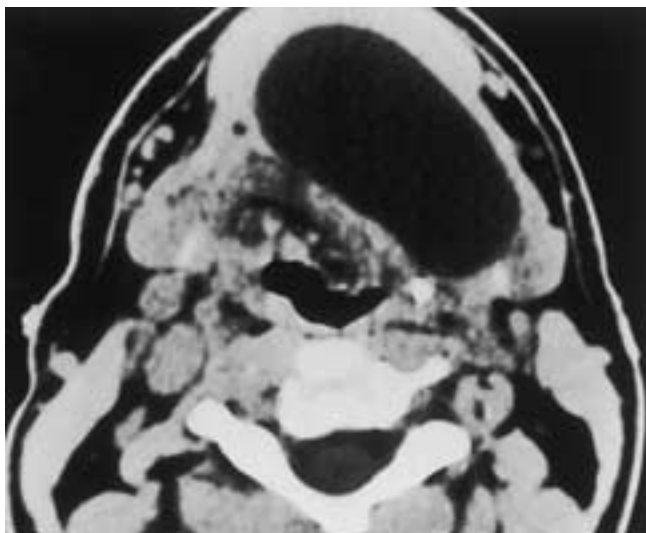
Epidermoid cyst. Axial CT scan reveals a large, unilocular, hypodense cystic lesion in the floor of the mouth. From an imaging standpoint, this appearance is consistent with either an epidermoid or a dermoid cyst.
